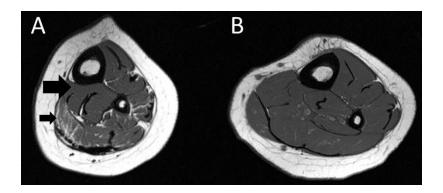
Magnetic resonance images from a boy with cerebral palsy (CP; A) and a typically developing boy (B) both 8.5 years of age at the level of the midtibia. The boy with CP had much lower muscle mass (large black arrow in A) and much higher intramuscular fat (smaller black arrow in A) compared to his typically developing peer.
